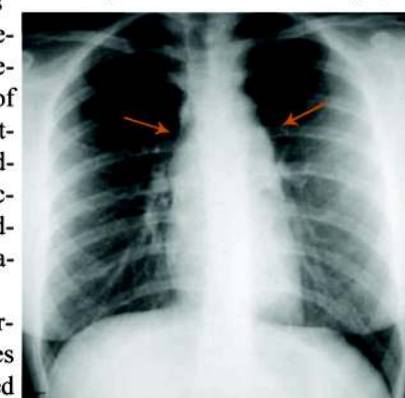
Hilar enlargement in chest radiograph in a young female patient of Takayasu arteritis
